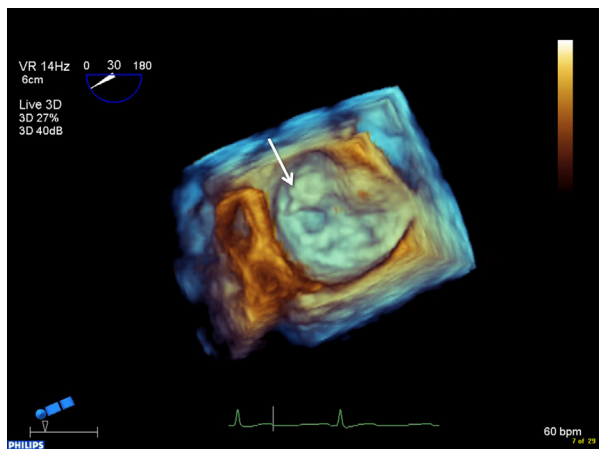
Still frame image of a three-dimensional echocardiographic en face view of the mitral valve with a flail A1 scallop (arrow) before left single orthotopic lung transplant.
